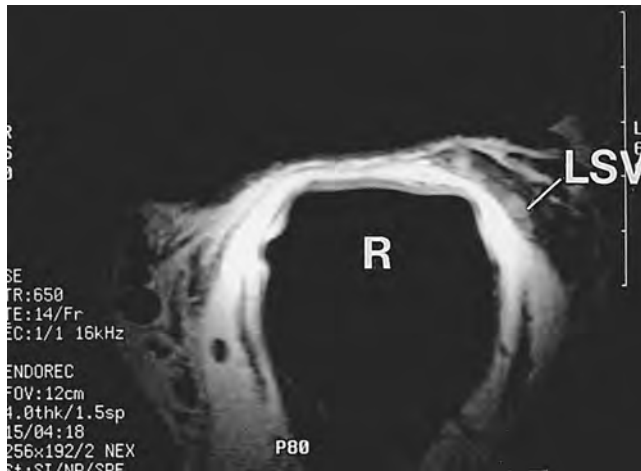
Transaxial T1-weighted endorectal magnetic resonance image of absent right seminal vesicle. LSV, left seminal vesicle; R, rectum.
